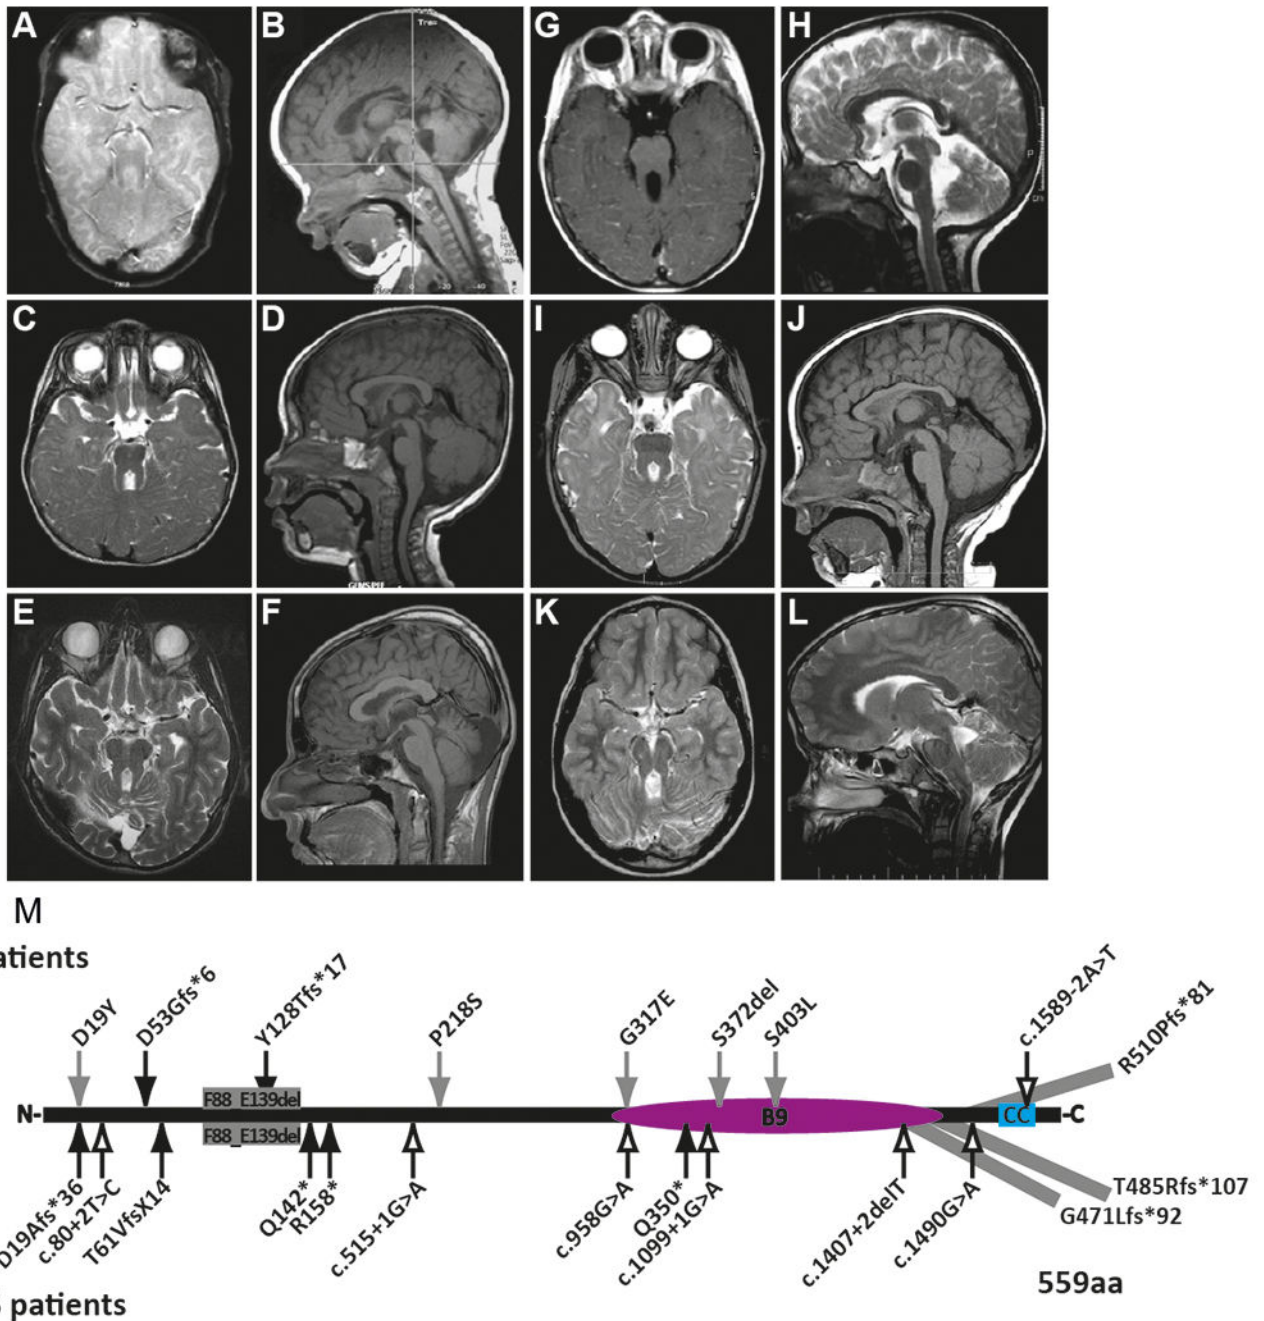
MRI findings and mutations in individuals with *MKS1*-related Joubert syndrome
